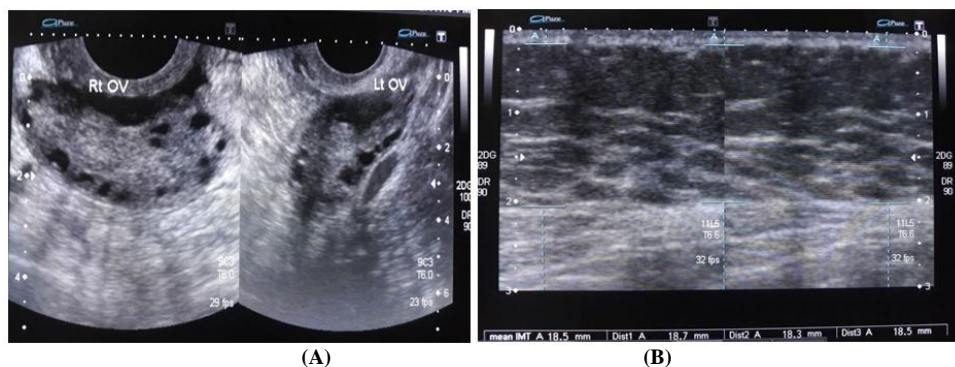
The transvaginal ultrasound image gives the sonographic appearance of PCOS. The transabdominal ultrasound image shows the measurement of subcutaneous fat thickness at suprapubic region. (Married, age 19years)
